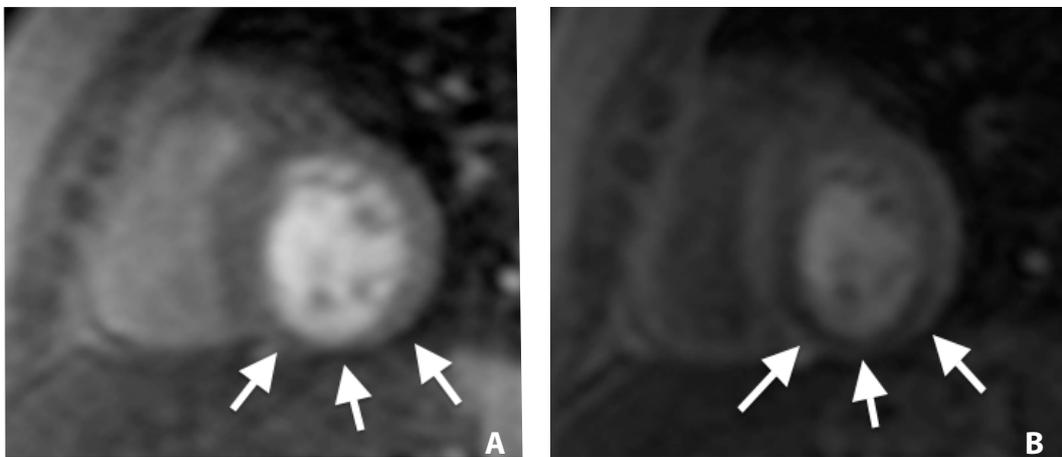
Myocardial perfusion imaging by MRI during the first pass of an intravenously injected contrast bolus. Rest image (A) shows a small subendocardial defect in the infero-septal wall. In the stress image (B) there is a large subendocardial perfusion defect in the inferior, septal and infero-lateral wall (arrows), confirming the presence of acute ischemia.
